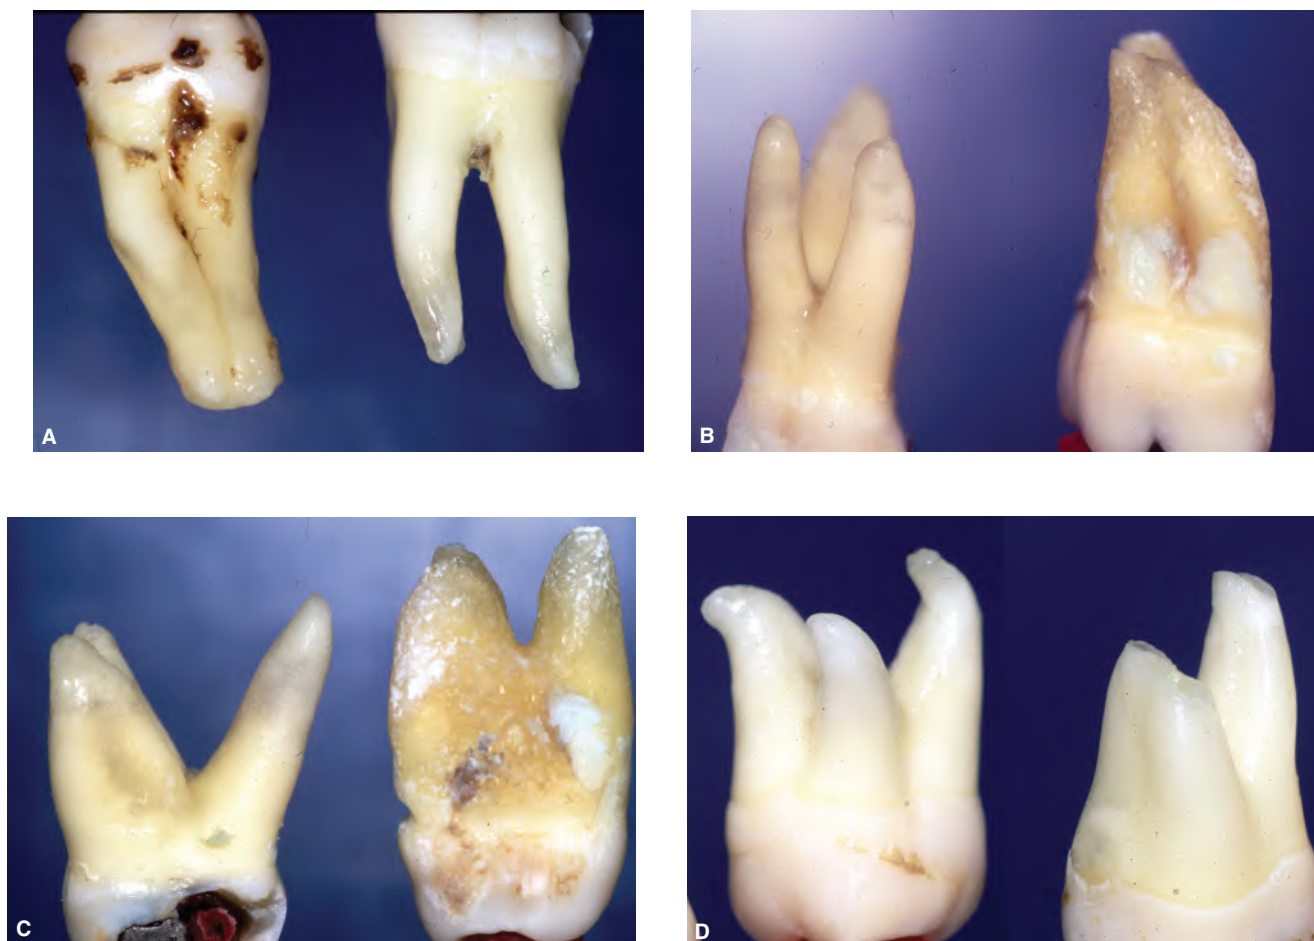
Root configurations and curvatures play a significant role in the success of the extraction. A,B. When the roots are fused (left tooth in A, right tooth in B), the extraction may be less complicated. Surface invaginations and concavities provide a positive index for replantation and resistance to exarticulation. The exception to this is when there is a partial fusion, with the apical segments joined, but the furcation separation is intact. In those instances, if there is significant bone through the furcation, conservative extraction without hemisecting the two roots may be impossible. C. When the root curvatures are mild, and have a similar orientation and direction, the tooth can be delivered along the appropriate path of draw. However, if the roots are widely divergent (left tooth), then fracture of either the root(s), cortical plate(s) or both is likely to occur. D. When the root-ends are severely dilacerated, fractures often occur at the angle of the dilacerations. The level of the fracture frequently coincides with the planned level of the resection (right tooth). Nevertheless, the orphaned root tip and any associated pathology must be delicately and completely harvested from the socket. Failure to do so may result in persistent periapical inflammation and incomplete replantation. Postoperative stabilization of multi-rooted teeth is generally a minor concern, even for teeth with fused root forms.
